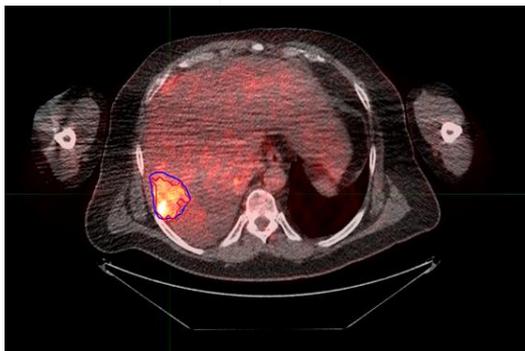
Example of PET/CT scan with expert and PARS segmentations
